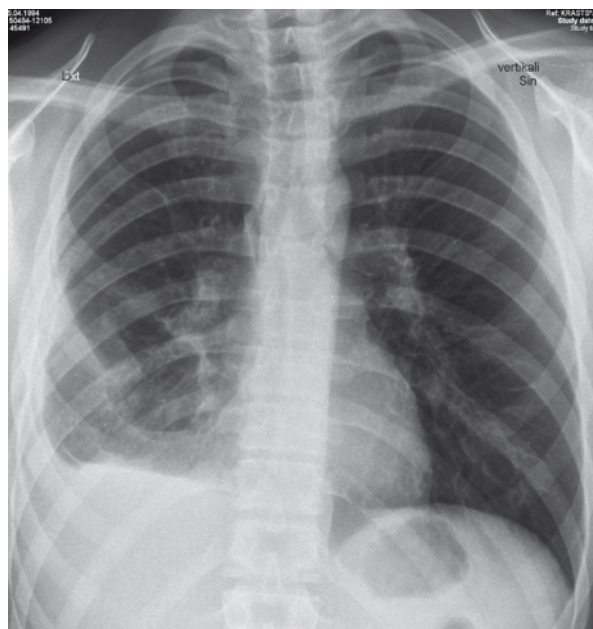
Chest X-ray when the patient was discharged after resection of middle part of the right lung with clinical improvement
